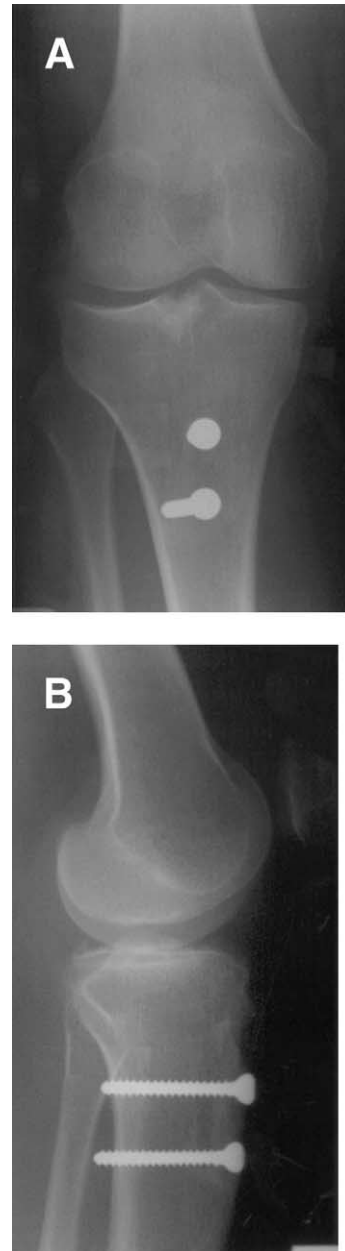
Thirteen-month postoperative (A) AP and (B) lateral radiographs of a patient who underwent a lateral meniscal transplant with concurrent autologous chondrocyte implantation and a distal realignment procedure. They show a healed allograft bone bridge without any radiolucency or cystic lesions.
